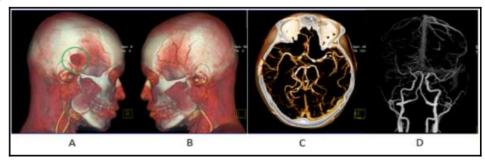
Head CT Angiography after cerebral bypass surgery procedure. Volume-rendered image right lateral view (A) with burr hole after surgery (green circle), left lateral view (B), Axial view (C) dan bone subtraction(D). Intracranial blood vessels are normal.
